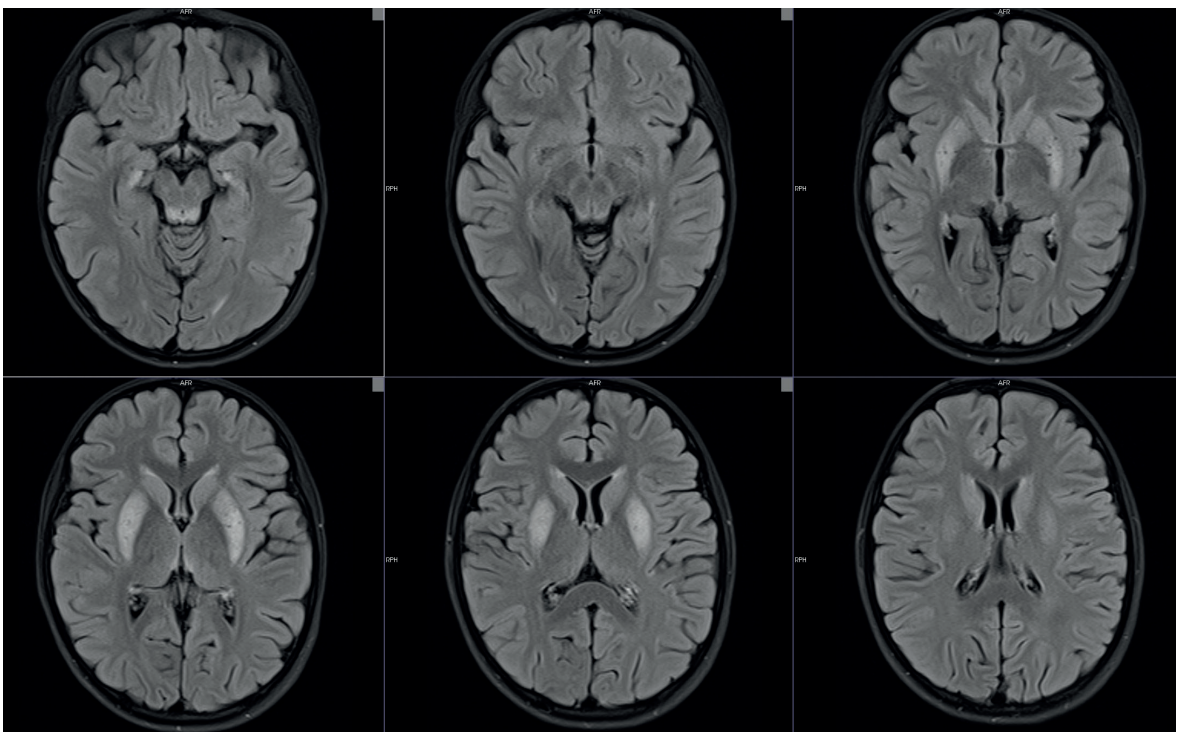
DWI sections showed symmetrical hyperintensity in medial thalamus, in the posterior part of the putamen, in the mesencephalon (tectum), in the periductal region, at the level of facial colliculus, and in the mammillary body.
